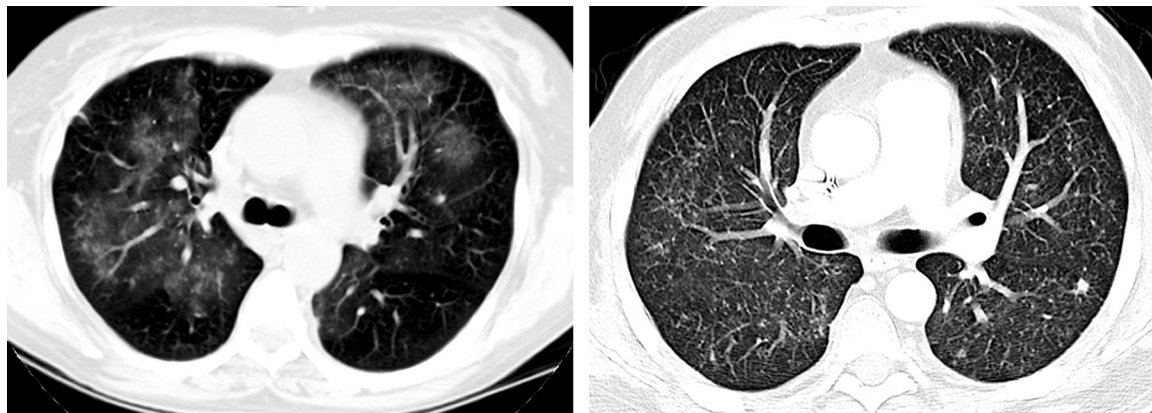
CMV pneumonia following hematopoietic stem cell transplantation. CT scans obtained in two different patients show small nodules, along with patchy (a) and diffuse (b) ground-glass attenuation.
